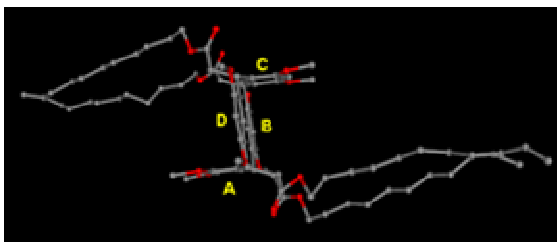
X-Ray structure of undecenyl resorc[4]arene 1a showing the *chair* conformation adopted by the macrocycle. Colors are as follows: C, grey; O, red. Hydrogen atoms are omitted for clarity.
